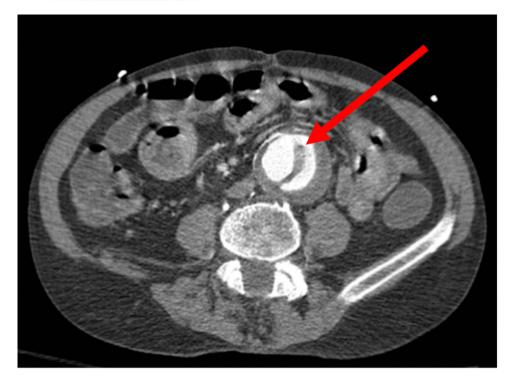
Computed tomography with an axial image showing a 5.2 cm infrarenal abdominal aortic aneurysm with an eccentric dissection flap (red arrow) and mural wall thrombus. Contrast is seen on both sides of the dissection flap
